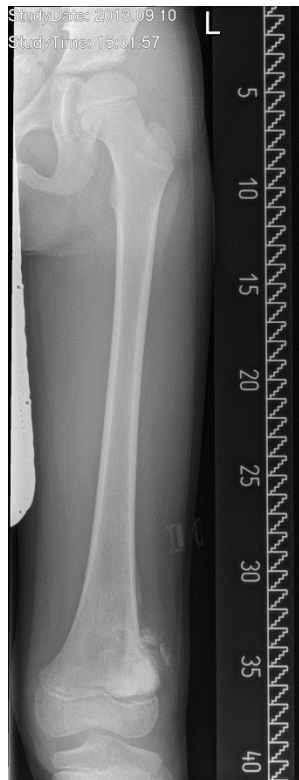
10 year old male patient of the Department of Orthopaedic Surgery Graz: X-ray a.p. of the left femur- osteosarcoma of the distal femur
